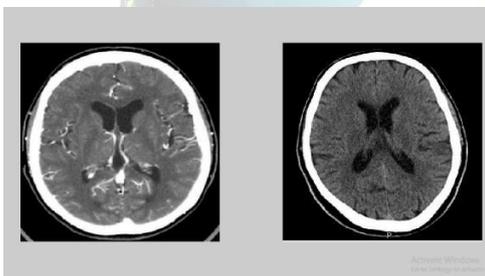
example image from CT and MRI input medical image.
